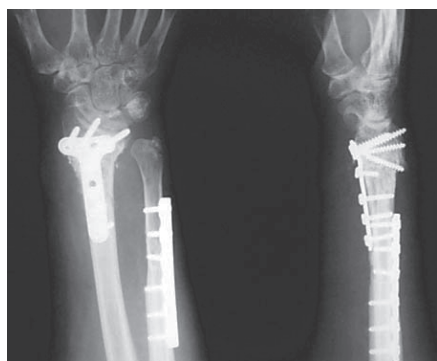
Radiographs on PA and lateral planes, showing bone union after 24 weeks of surgical treatment of pseudoarthrosis of distal radius fracture in patient number 2.
